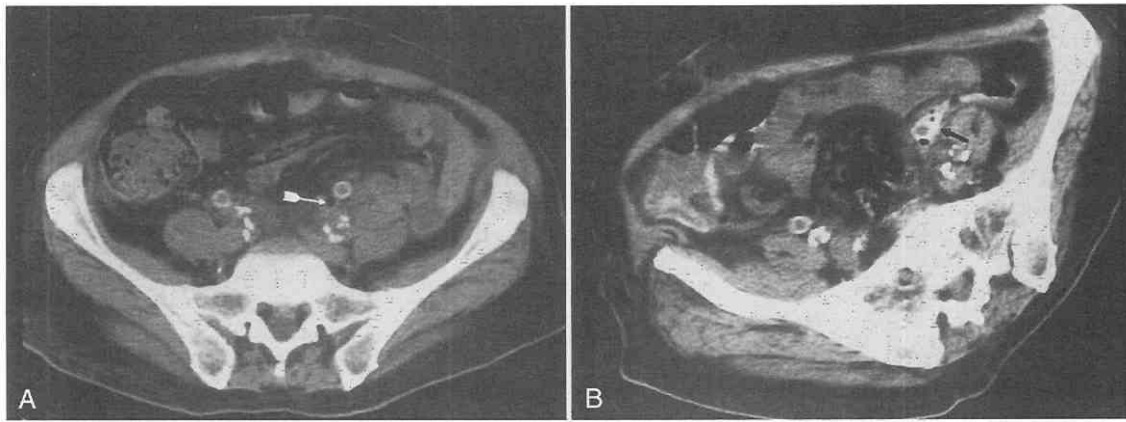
Infection caused by fistula. A, CT scan shows a small air collection (arrow) adjacent to the left iliac limb of a prosthetic graft. B, Communication with the colon is verified by leakage of contrast material (arrow) from the bowel to the graft.
